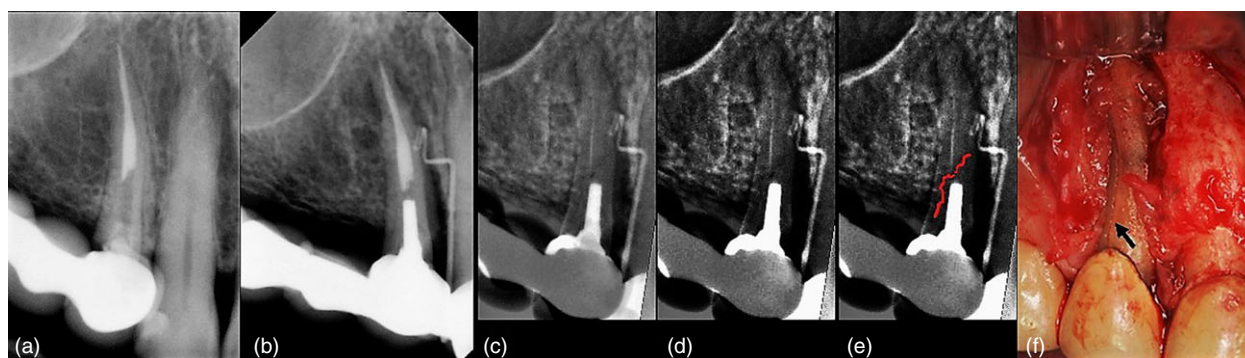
(a) Post-operative radiograph. (b) After 5 years: 'J-shaped' radiolucency in the mesial area and the apical third of the root. No fracture line is visible. (c) Result of digital subtraction of b from a: an oblique dark line in the body of the root is evident at its mesial part. (d) DSI processed using CET. (e) Image d processed using PCT. (f) VRF revealed after flap reflection.
